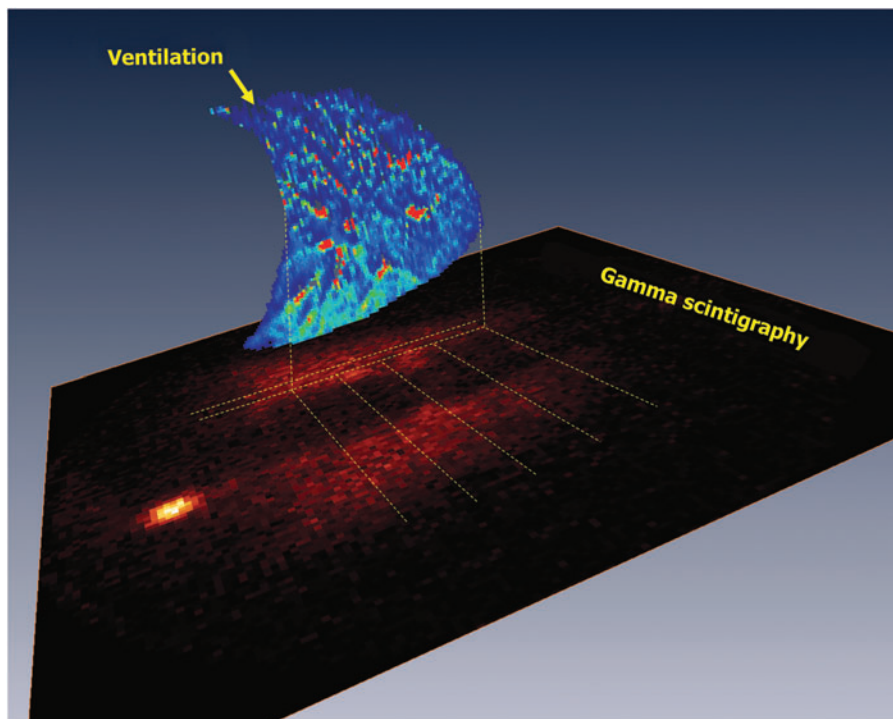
Gamma scintigraphy acquired deposition scan, with a sagittal map of ventilation of a 15 mm slice of the right lung superimposed. The ventilation in each cranio-caudal quartile was integrated to estimate total ventilation to each region, indicated by the parallel dashed lines. Images were co-registered.
